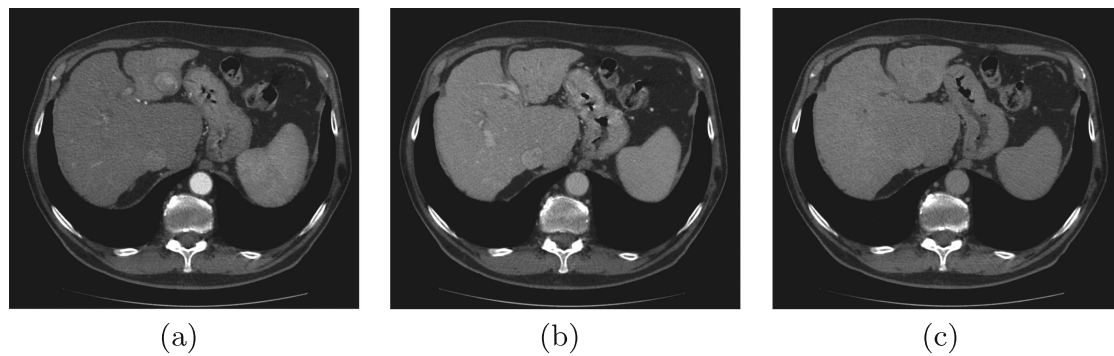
CT images acquired in the different phases: (a) arterial phase; (b) portal phase; (c) equilibrium phase
